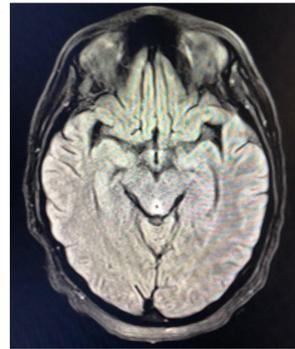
axial slices, unenhanced magnetic resonance imaging of the brain at the level of the mammillary bodies and aqueduct, T2/FLAIR sequence.
